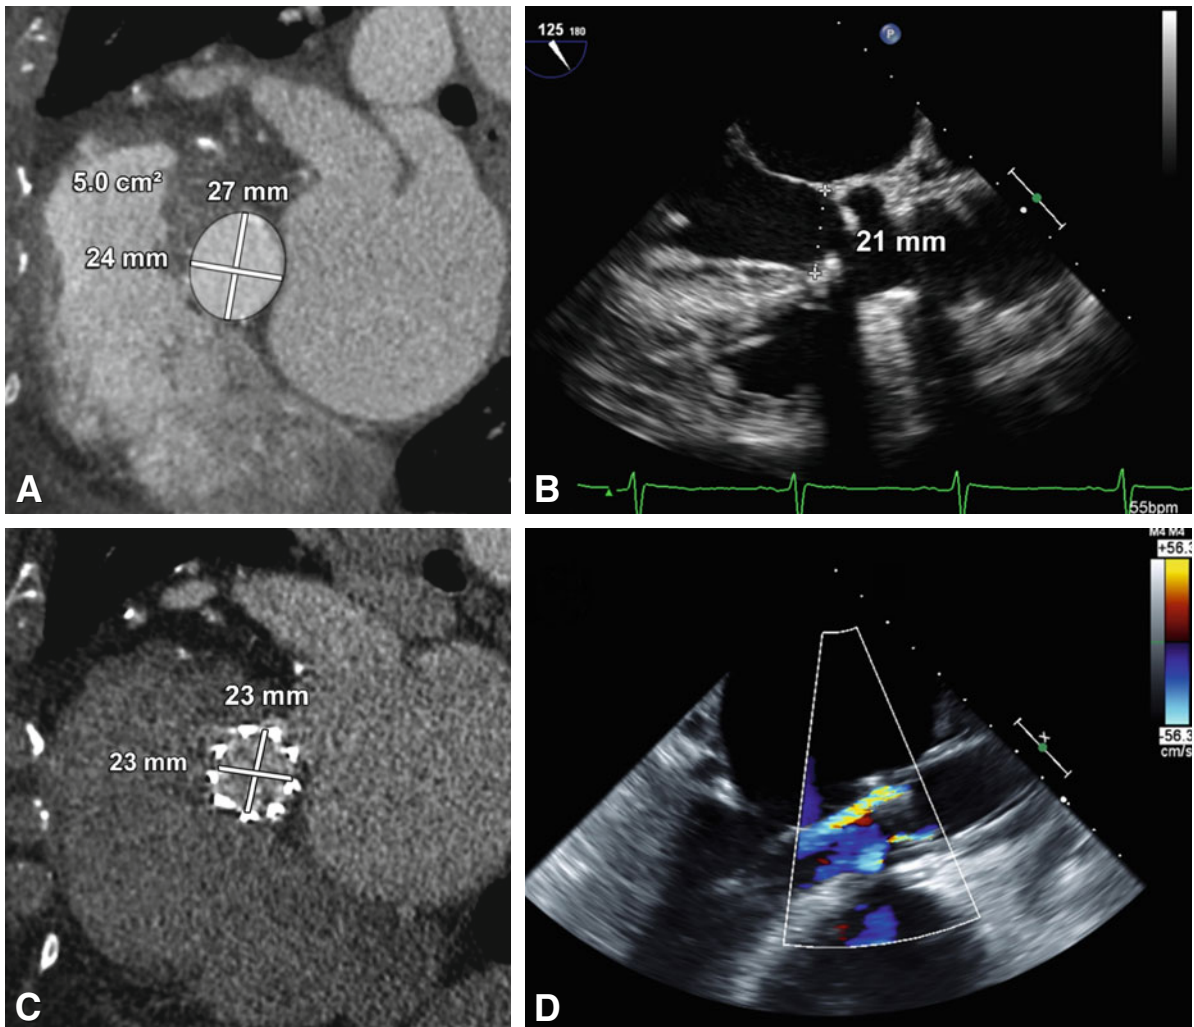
Moderate paravalvular regurgitation post TAVI owing to annular undersizing by echocardiography in an 81-year-old female patient with severe symptomatic aortic stenosis. A double-oblique reconstruction of the basal ring by CT (Panel A) shows an annular area of 5.0 cm² and dimensions of 24 and 27 mm. The parasternal long-axis transthoracic echocardiography measurement of the annulus was only 21 mm (Panel B), which supported the deployment of a 23-mm balloon-expandable transcatheter heart valve. CT after implantation shows a circular 23-mm valve which appears well positioned (Panel C). However, postimplantation echocardiography shows moderate paravalvular regurgitation, most likely related to annular undersizing, which might have been avoided with the use of preprocedural CT measurements for valve sizing
